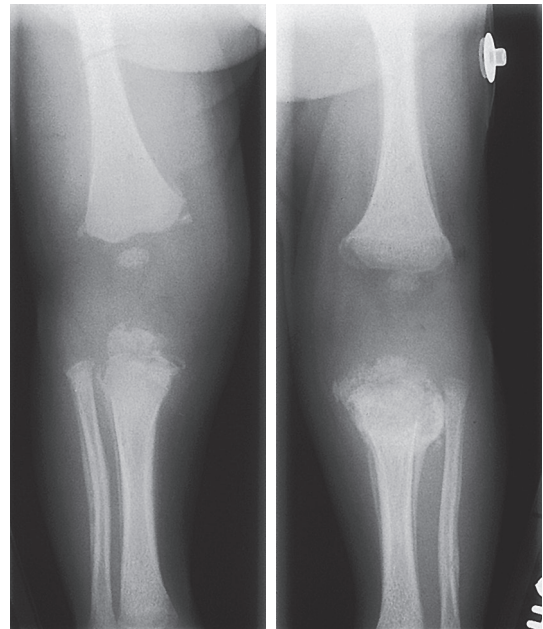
Corner Fracture. Bilateral knee radiograph showing healing corner fractures of bilateral proximal tibias and distal femurs. Note the varying amount of callus formation signifying fractures at different stages of healing.
